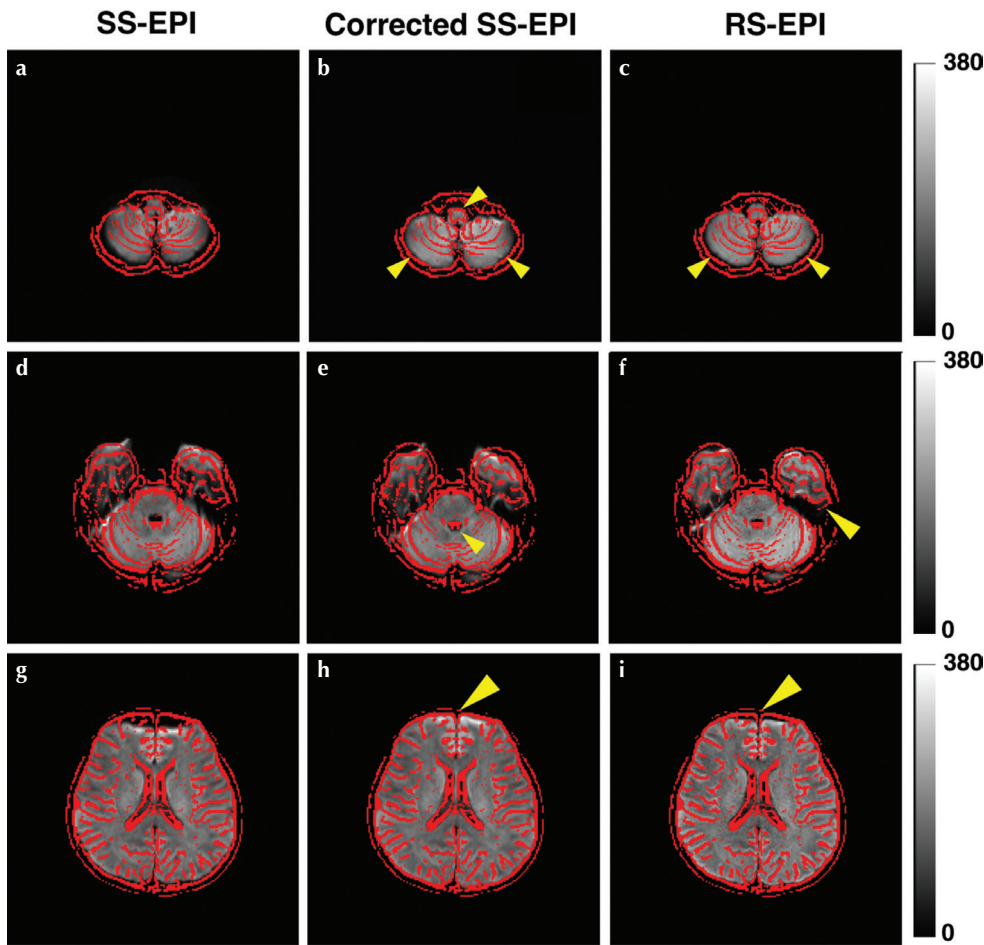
SS-EPI DWI, corrected SS-EPI DWI, and RS-EPI DWI images from a single subject. Edges from the FSE- T_2 WI are overlaid in red on SS-EPI (a, d, and g), corrected SS-EPI (b, e, and h), and RS-EPI (c, f, and i). The displacement from the red line in each corrected DWI is less than that in the SS-EPI (arrows). FSE- T_2 WI, fast spin-echo T_2 -weighted image; RS-EPI DWI, readout segmented-echo planar imaging diffusion-weighted image; SS-EPI DWI, single shot echo planar imaging diffusion-weighted image.
